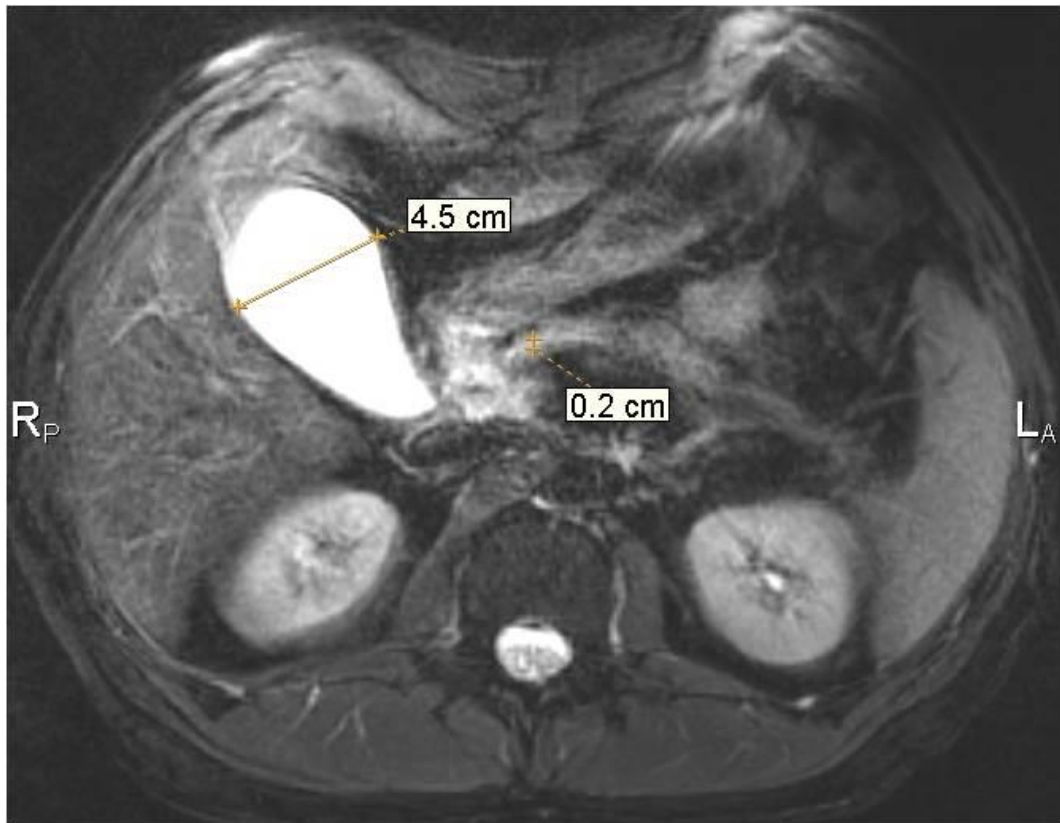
MRI of the patient K. August 24, 2016 MR-sequence T2VI, axial plane of scanning, FatSat (fat suppression). Gall bladder of Ivirsungian duct (up to 2 mm).
